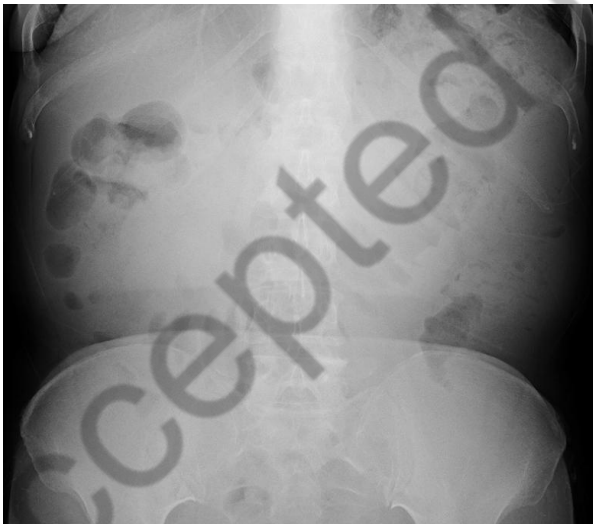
Abdominal radiograph after IVIG therapy.
